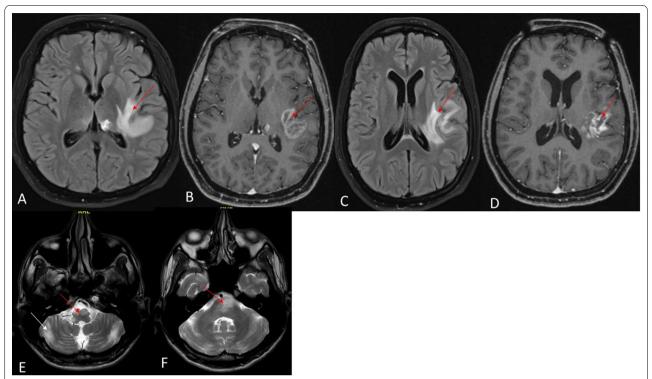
MRI brain of patient 2 (A–D). A, C axial FLAIR images show hyperintense lesion in left thalamus, internal capsule and peri-insular region (red arrows); B, D 71- contrast images show contrast enhancement in left thalamus, internal capsule and peri-insular region (red arrows); E, F axial 72 images of patient 7 shows hyperintense lesions in medulla, cerebellum and pons (red and white arrows)
